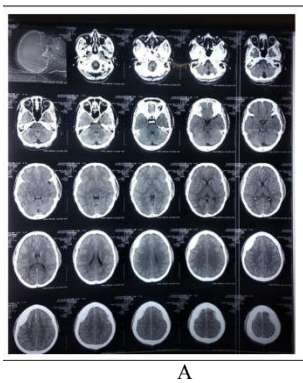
Figure I (Patient 1): Hematoma size increased but surgery not required. Patient was treated conservatively. (a) CT head on admission (b) CT head on 3rd post admission day .
